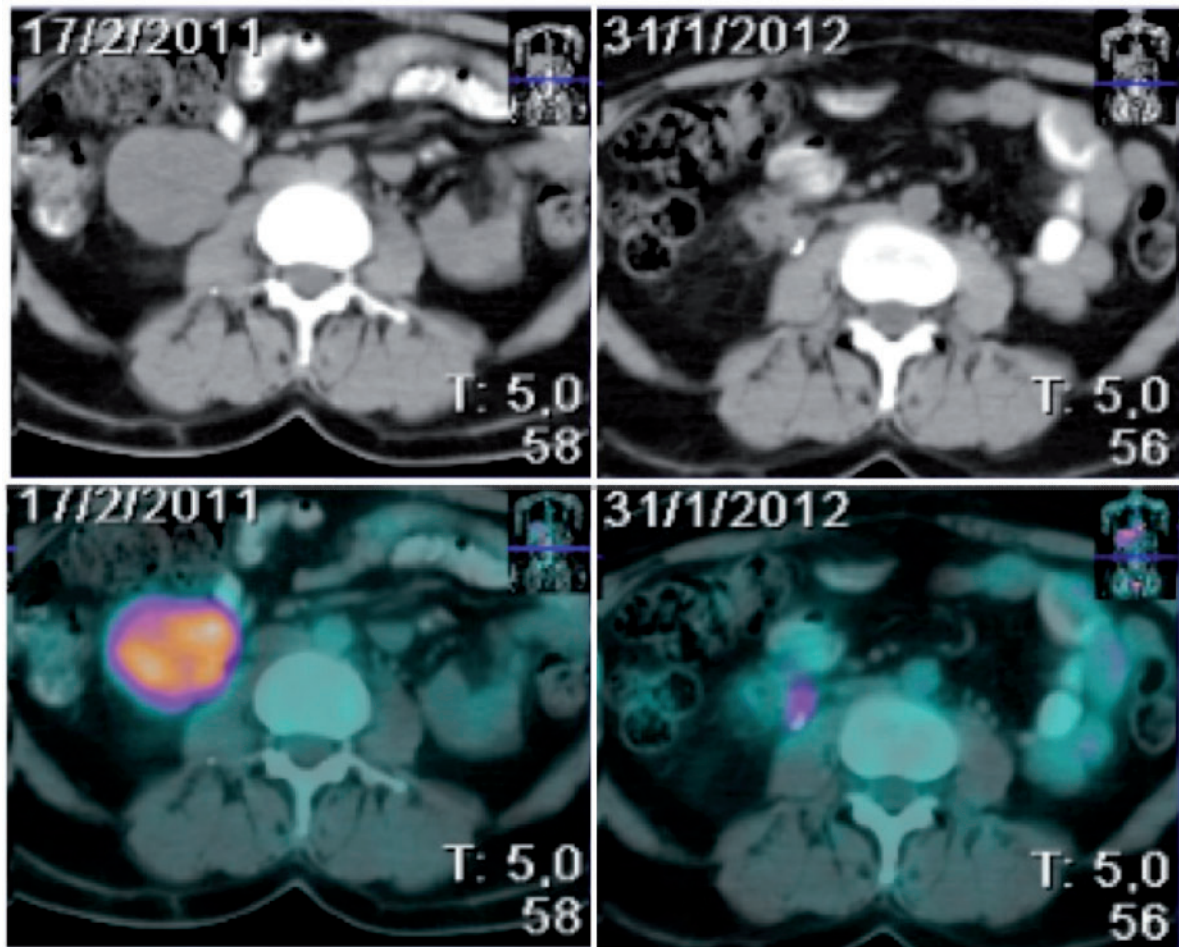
Morphologic (top) and metabolic (bottom) evolution of the retroperitoneal mass before (left) and after (right) treatment, including chemotherapy and tumor ablation. Although mild residual fluorodeoxyglucose uptake (SUV_{max} 2.1) was observed in the medial aspect of the node after treatment, this finding was not considered qualitatively significant.
